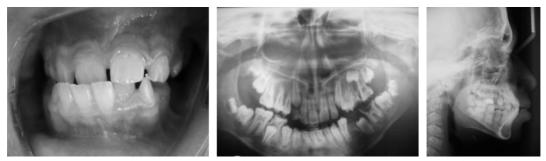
Photograph and panoramic and cephalometric radiographs show intraoral view of normal permanent dentition development with anterior crossbite in case 2.
